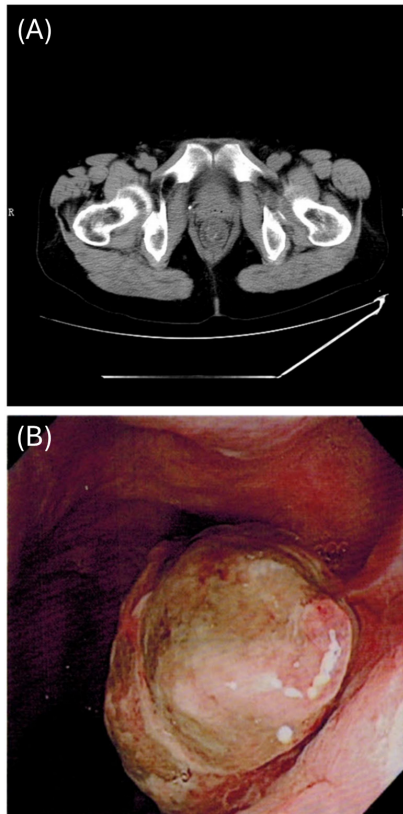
(A) Abdominal computed tomography scan showing a malignant rectal lesion, and (B) Colonoscopic view of the rectal tumor.
